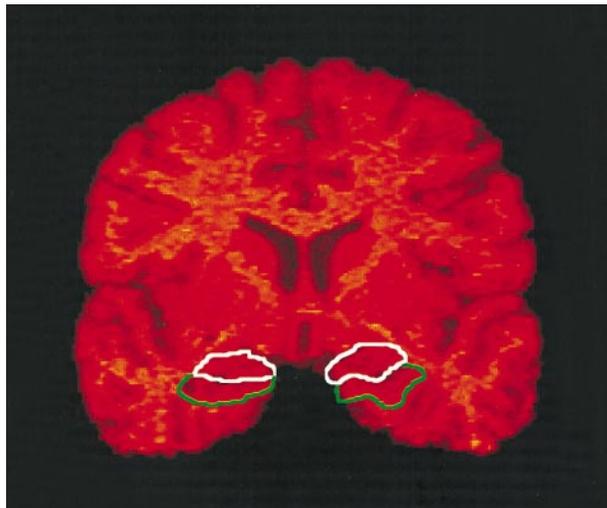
Examples of manual tracings of the hippocampus (green line) and the amygdala (white line) from a reformatted coronal magnetic resonance image.
